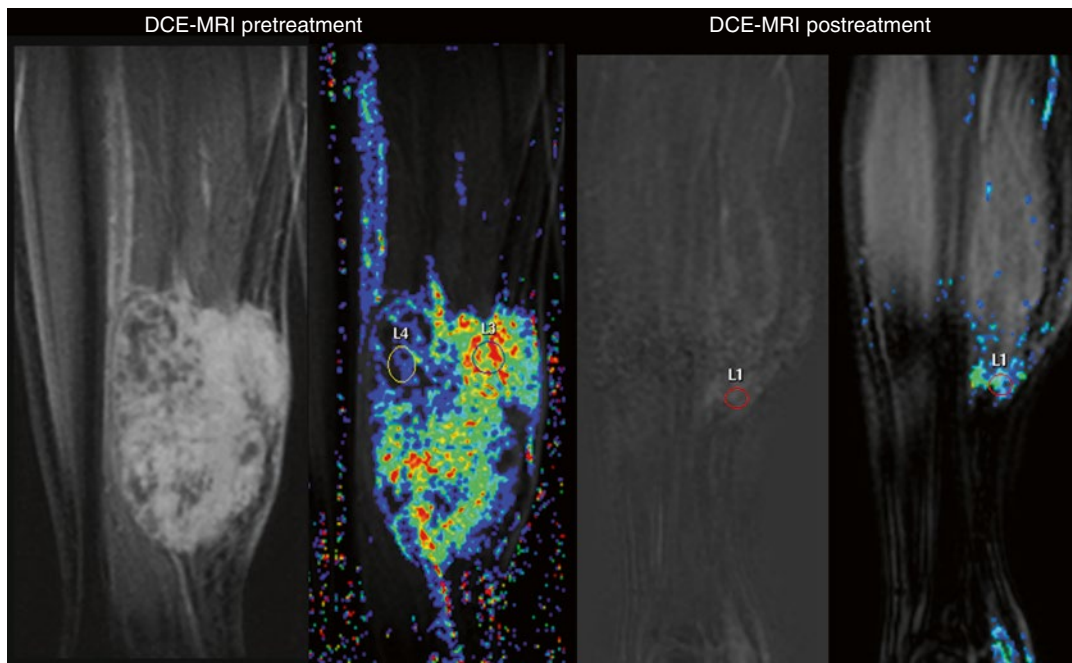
Soft tissue Ewing sarcoma. Pretreatment MRI shows an aggressive soft tissue mass highly vascularized in DCE-MRI acquisition and maximum relative
